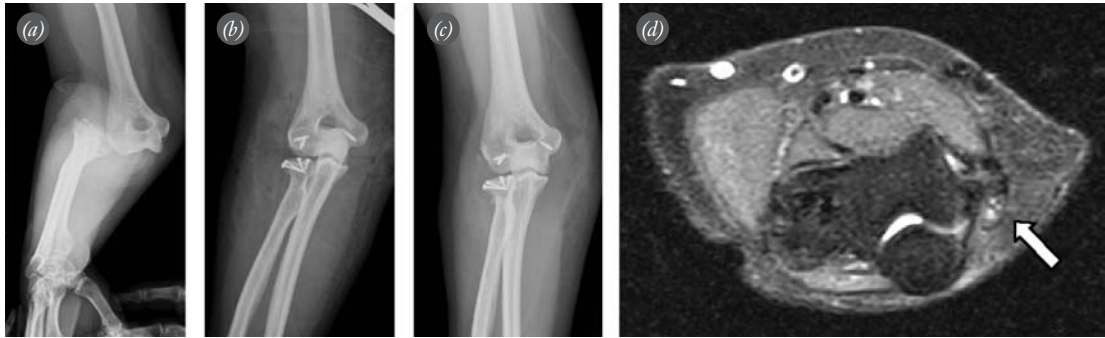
(a) Preoperative and (b) early postoperative radiographs of a 45-year-old woman with a right terrible triad injury of the elbow. Surgical repair consisted debridement of the small coronoid fragments and fixation of the anterior capsule, radial head fixation with screws, lateral and medial collateral ligament repair by suture anchors and cubital tunnel release. (c) Postoperative 16th month radiographs demonstrate negligible amount of ectopic ossification at the medial epicondyle. (d) MRI shows near normal insertion of the injured MCL to the medial epicondyle and a normal cubital tunnel. The ulnar nerve is detected at the cubital tunnel without any signs of entrapment (arrow).
